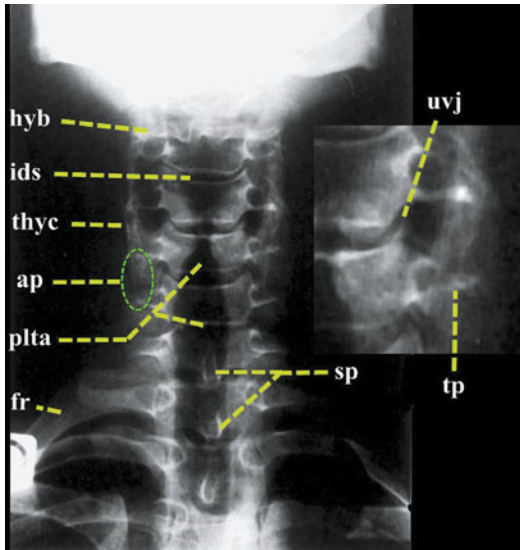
Conventional radiographic anatomy of the cervical spine in the anteroposterior projection. Hyoid bone (*hyb*); uncovertebral joint (*uvj*); intervertebral disk space (*ids*); thyroid cartilage (*thyc*); laryngo-pharyngo-tracheal airway (*plta*); transverse process (*tp*); articular process (*ap*); spinous process (*sp*); first rib (*fr*)
